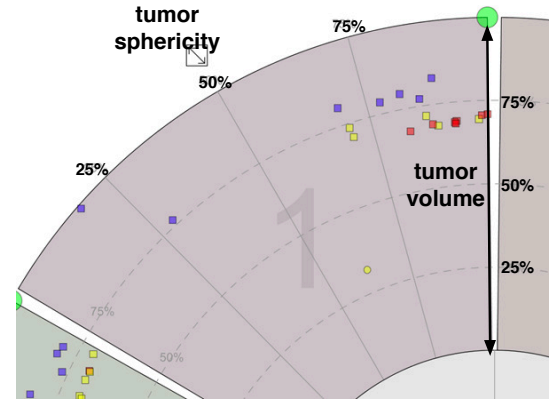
PET-CT Case Study – The selected (blue) nodes represent the images most similar to the refined query in terms of tumor size.
